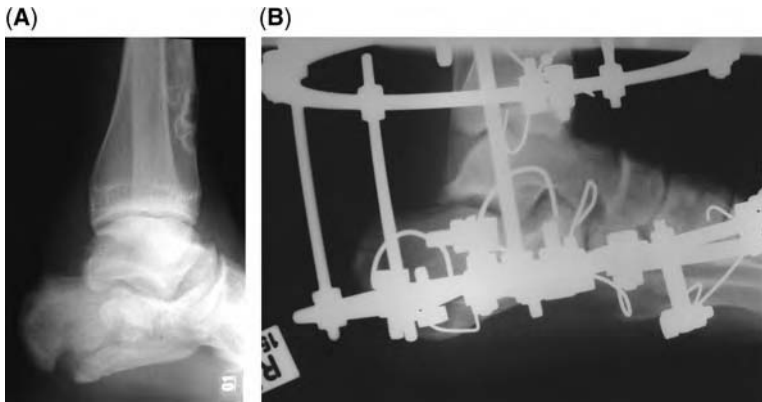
(A) X-ray of displaced intra-articular fracture of the calcaneus. (B) Postoperative X-ray following Ilizarov fixation of this calcaneal fracture.
